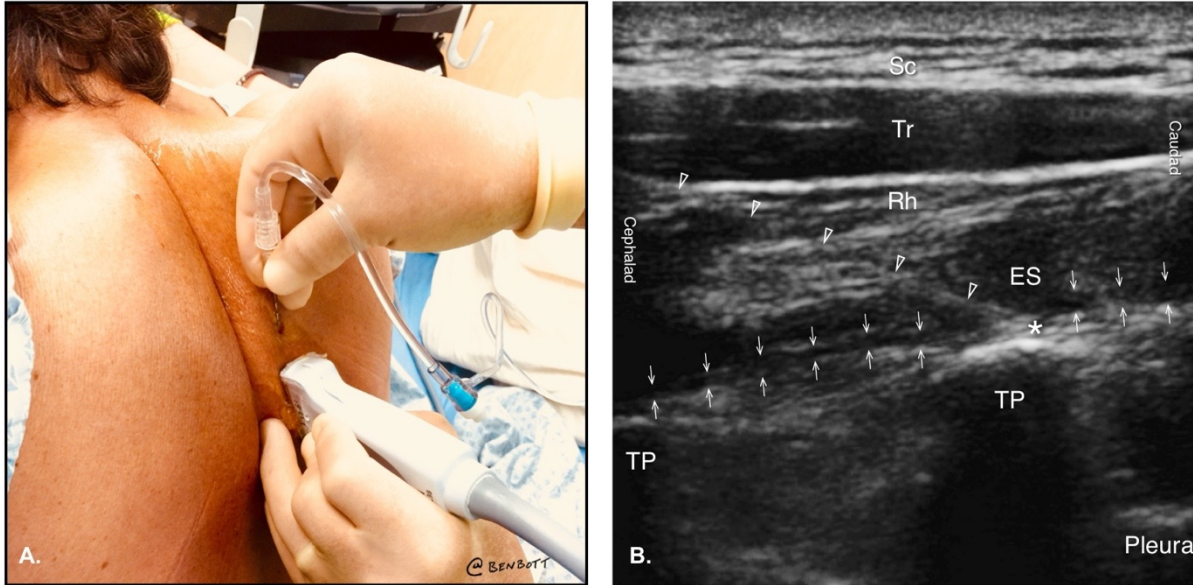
Insertion site and ultrasound view (image source: highlandultrasound.com)
